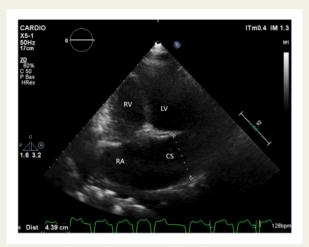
Figure I Transthoracic echocardiography, apical four-chamber view showing a dilated coronary sinus measured at 44 mm. CS, coronary sinus; LV, left ventricle; RA, right atrium; RV, right ventricle.
